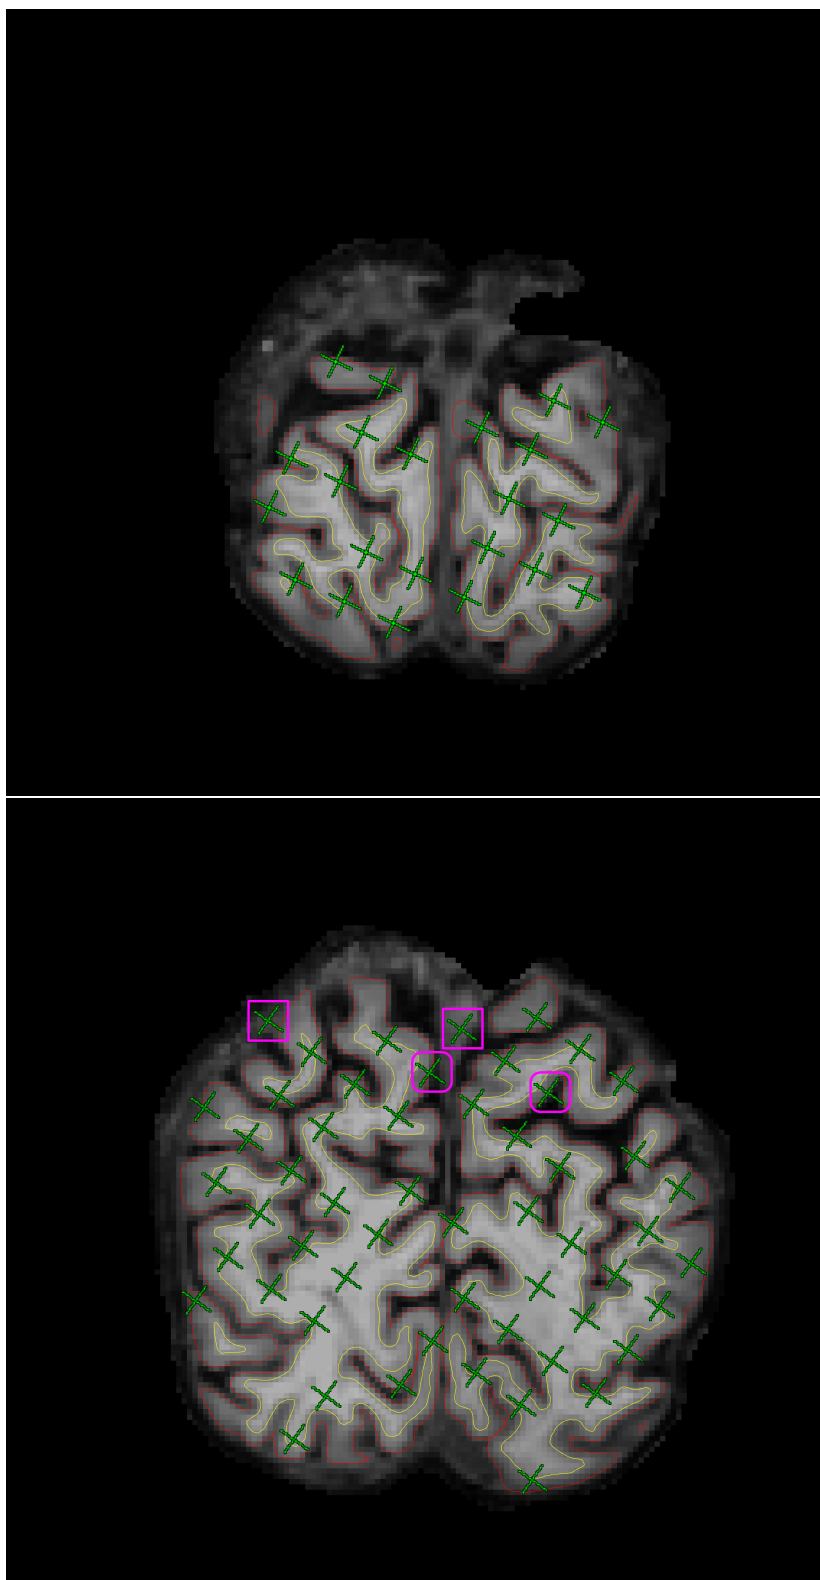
On the 2nd and 3rd slices of one brain MR image in the coronal view, counted test points (green) hitting the cerebrum (excluding ventricles) are overlaid onto pial profiles (red lines) segmented by FREESURFER. Rectangles (pink) mark the counted test points which fall outside the grey matter boundaries (red lines) and rounded rectangles (pink, racetrack-like) mark the test points hitting exactly on the grey matter boundaries.
